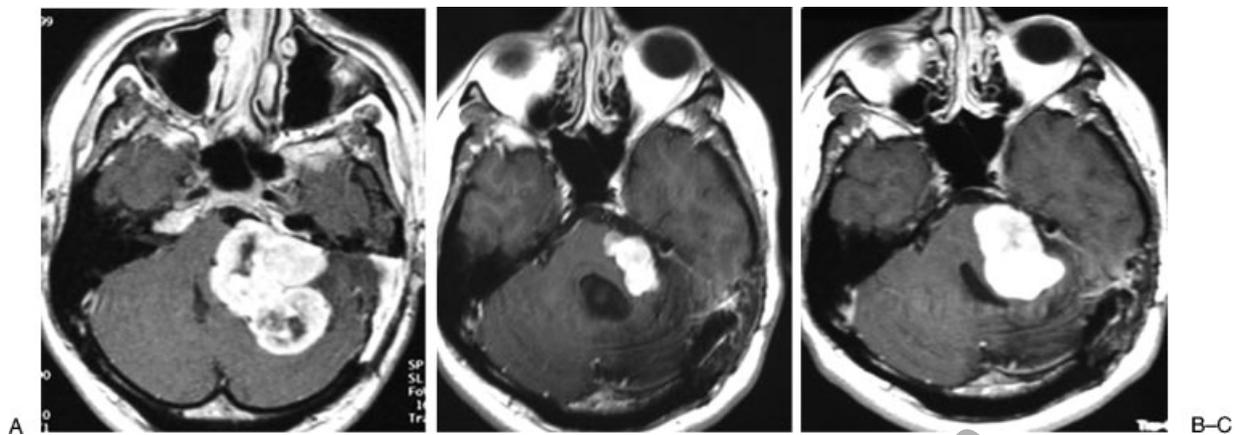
(A) Axial T1W MRI with contrast showing radiological recurrence consistent with symptomatic recurrence 2 years after original treatment (1999). At this time revision surgery was undertaken. (B) Stable radiological appearances in 2006. (C) In May 2007, when the patient re-presented with facial numbness and ataxia, MRI showed significance recurrence.
